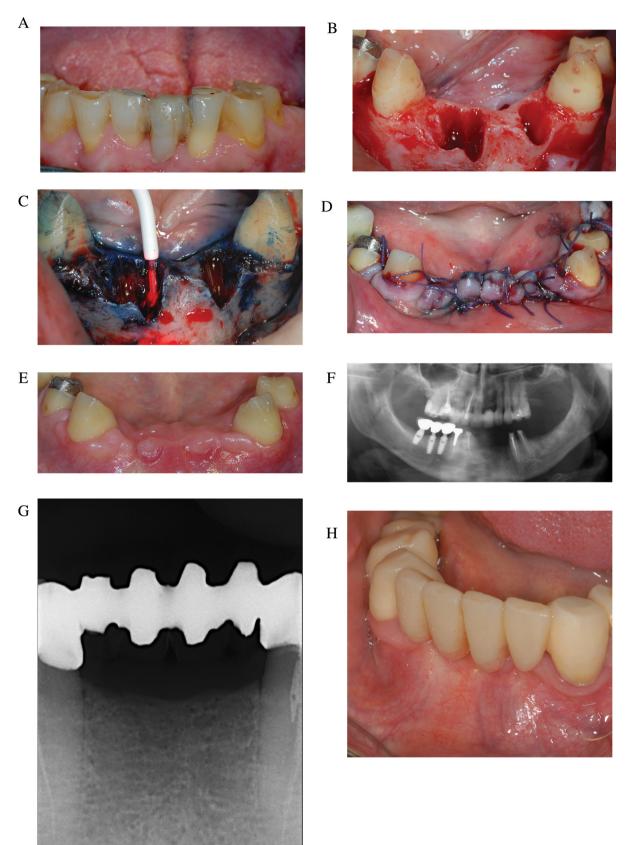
A – Pre-operative clinical view of periodontally compromised lower incisors supporting a resin-bonded fixed partial denture; B – Post-extraction alveolar sockets following removal of the incisors; C – Antimicrobial photodynamic therapy performed in the surgical area; D – First intention closure of the surgical wound with resorbable suture; E – Clinical healing of the soft tissues at the 6-month follow-up recall visit; F – Follow-up orthopantomograph performed after 6 months from the surgical procedure.
